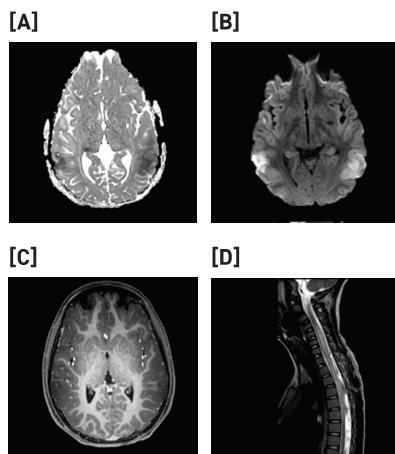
Head and spine MRI of the patient during admission
